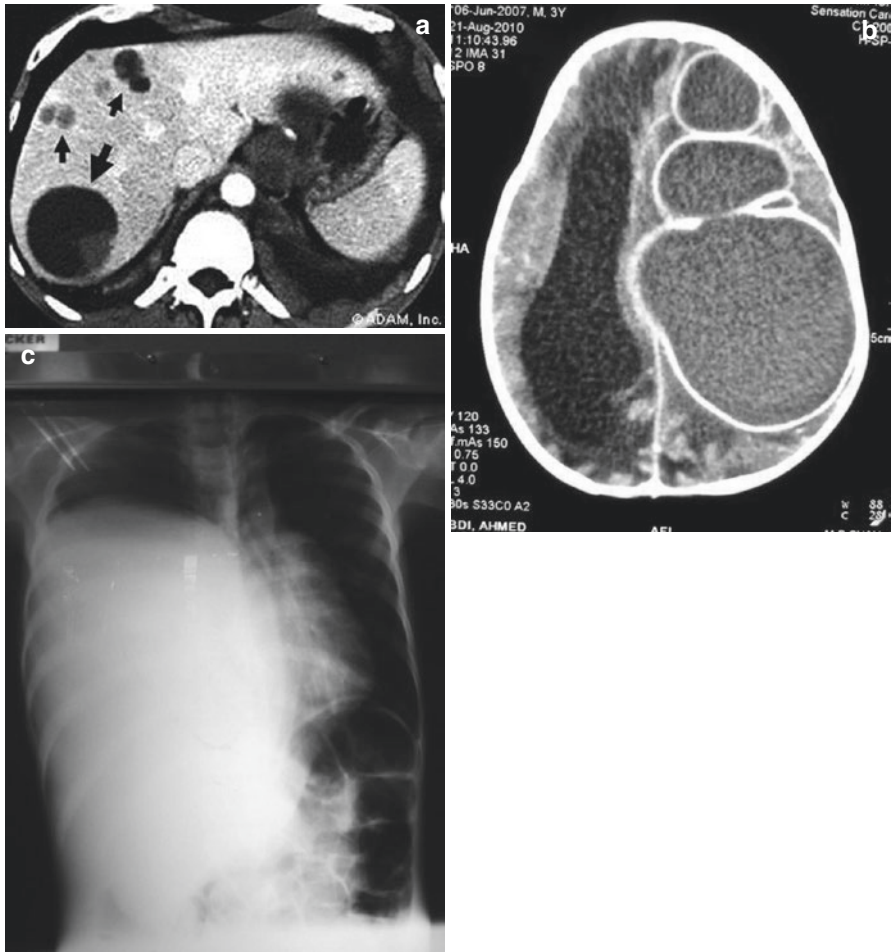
(a–d) The posterior subcapsular liver cyst shown on the *top left* (a) should probably be resected. Definitely, the cysts in the brain (b *top right*) should be removed (Photos courtesy Michael Matlak). (c *bottom left*) The chest x-ray of a patient with a huge right pulmonary hydatid cyst and the CT (d *bottom right*) which shows that it is predominantly one huge cyst (Photos courtesy Dan Poenaru)
